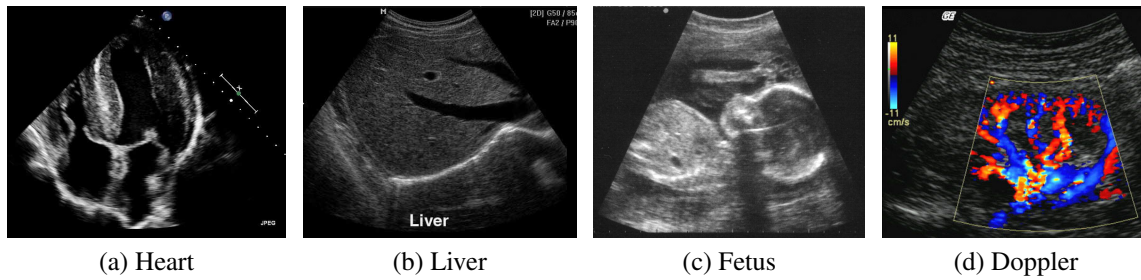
Example ultrasound images from the cardiac ((a)), gastric ((b)), fetal ((c)) and Blood flow (d) domain.
